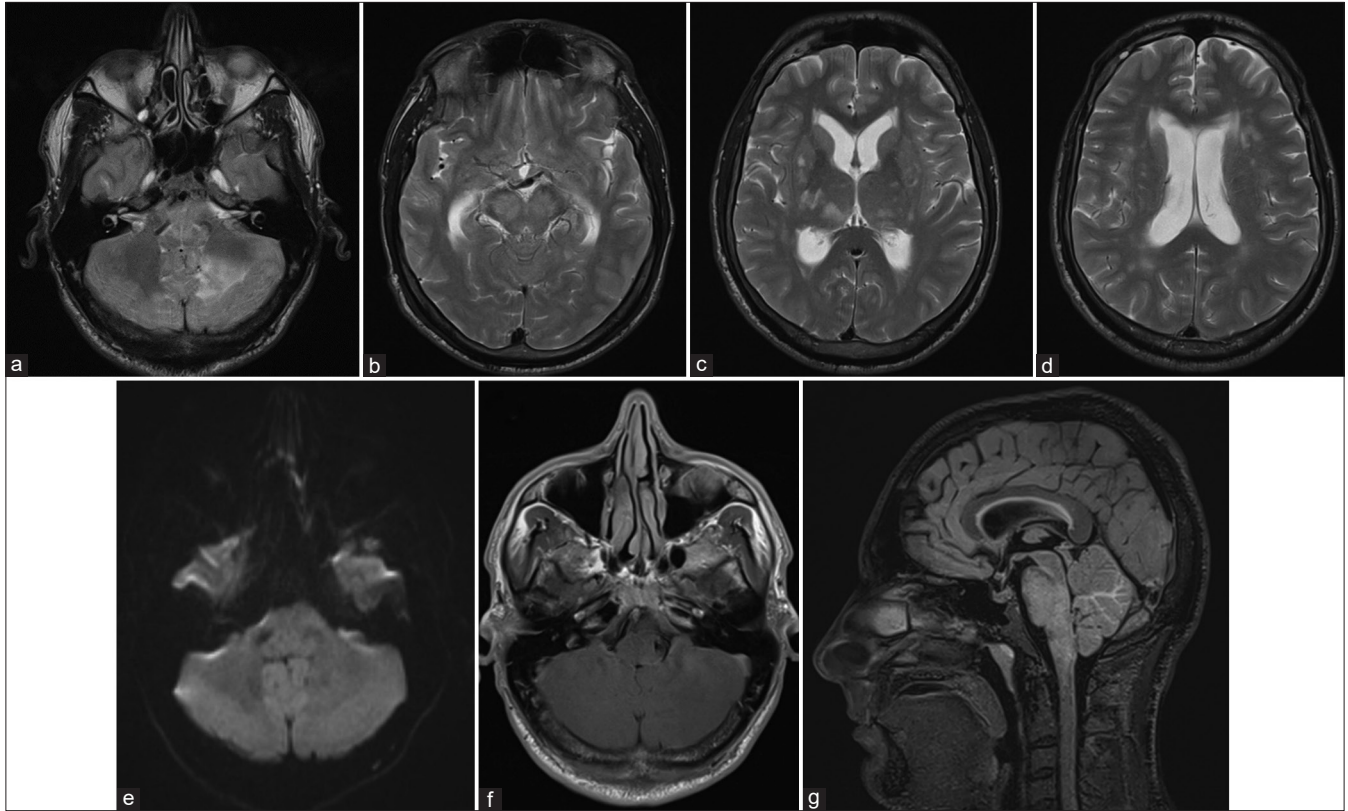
Initial magnetic resonance imaging showing T2/fluid attenuated inversion recovery hyperintensities in the cerebellum and brainstem (a, b, and g) and dilated lateral ventricles with periventricular hyperintensity (c and d). No infarction on diffusion-weighted imaging (e) or enhancing lesion on contrast-enhanced T1 imaging (f).
